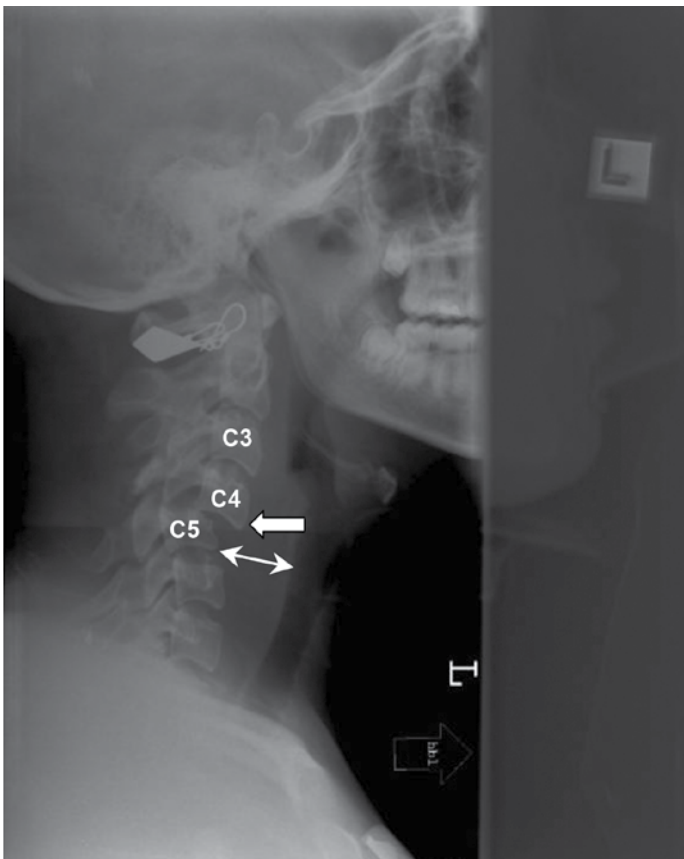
Lateral cervical spine X-ray of patient 2, showing anterior subluxation (shift) of C4 on C5 (arrow). There is considerable soft tissue swelling anterior to the fracture-dislocation (double arrow). The metallic object at the top of the cervical spine is an overlying ear ring.
